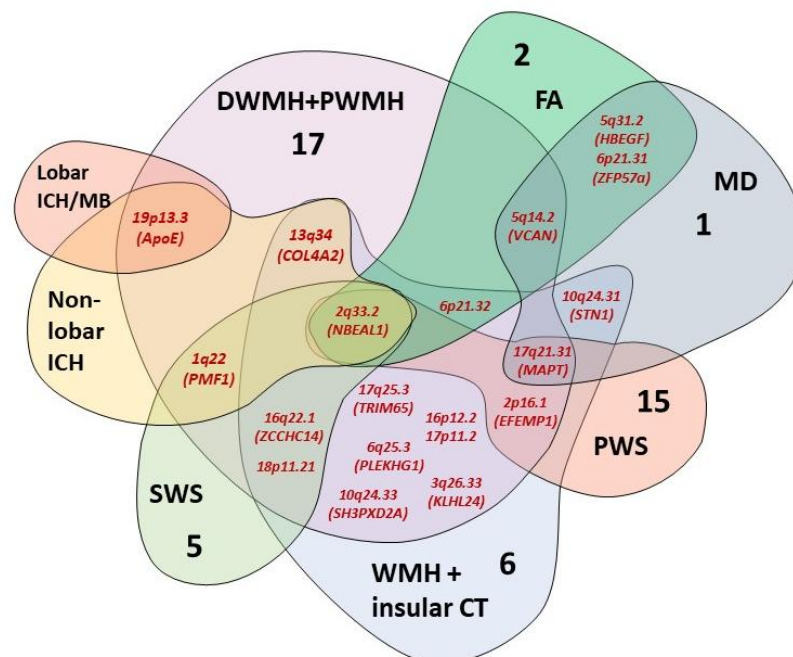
Overlap of GWAS-significant loci across CSVD MRI markers. Abbreviations: DWMH/PWMH – deep/periventricular white matter hyperintensities; ICH – intracerebral hemorrhages; MB – microbleeds; SWS – small vessel strokes (lacunar infarcts); PWS – perivascular spaces; FA/MD – fractional anisotropy/mean diffusivity of normal-appearing white matter; CT – cortical thickness. Numbers on the figure indicate unique significant loci for each of the MRI criteria.
